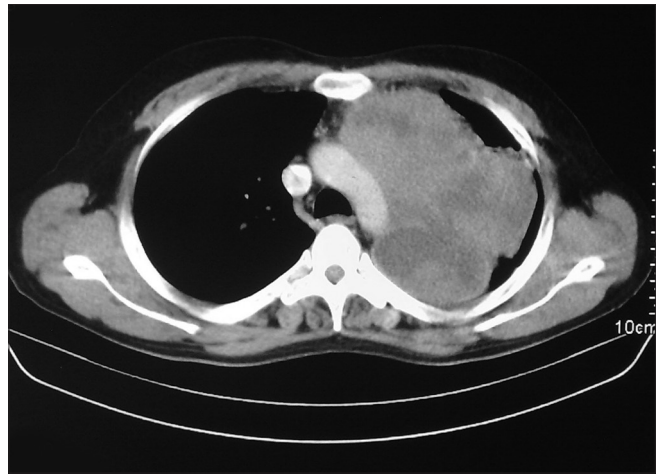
CT scan chest showing a large, soft tissue density mass at left upper lobe lung with central necrotic areas
